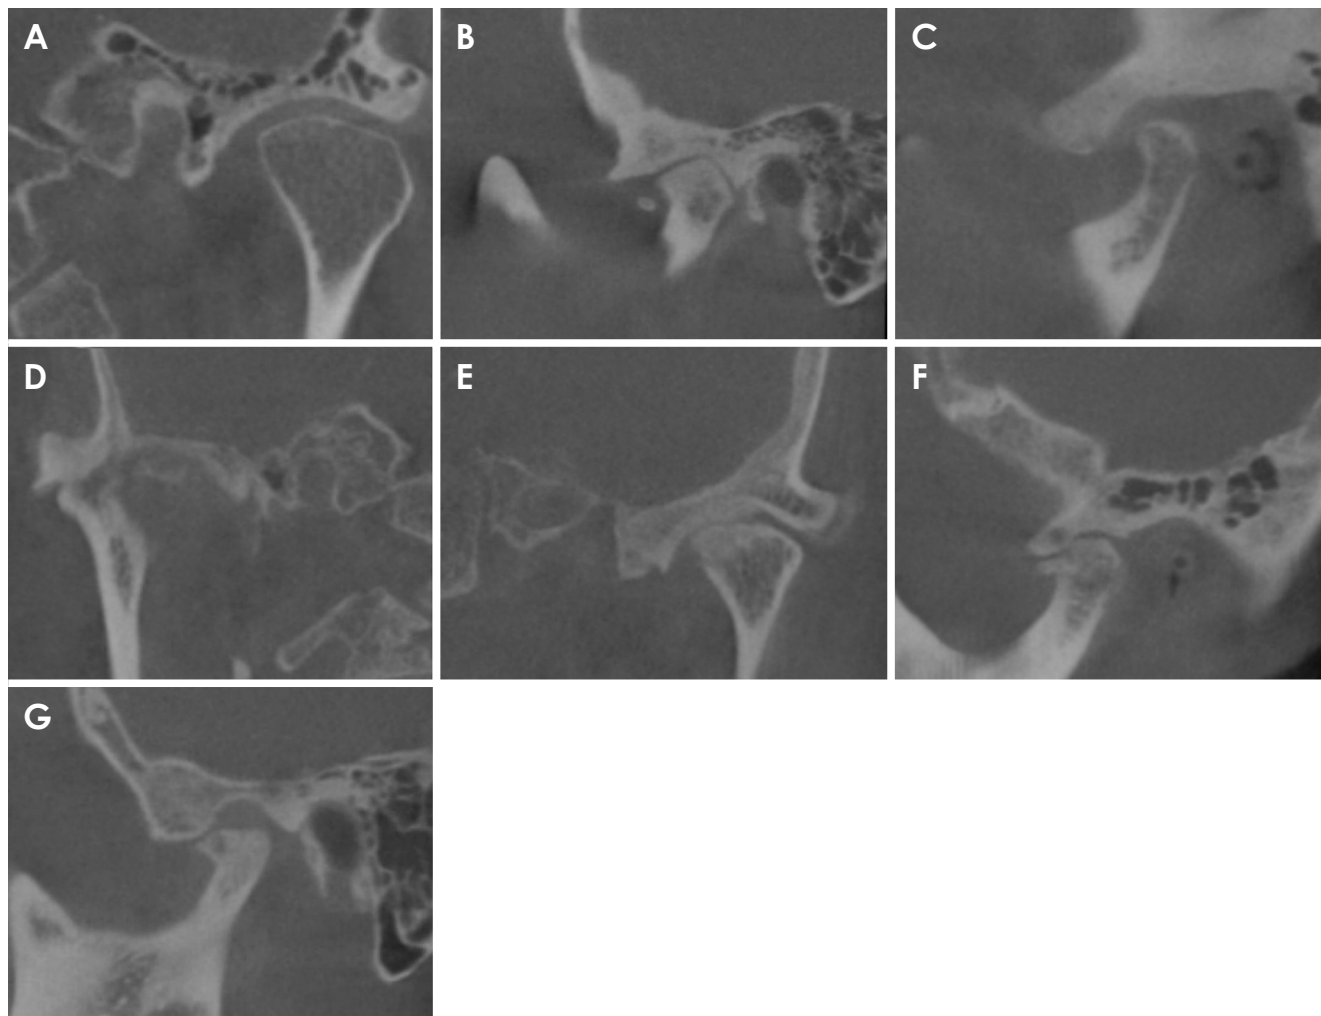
Sample cone-beam computed tomography images show bony changes in the temporal bone, selected from subjects in this study. A. Normal state (coronal view). B. Flattening (sagittal view). C. Erosion (sagittal view). D. Osteophyte (coronal view). E. Subchondral sclerosis (coronal view). F. Subchondral pseudocyst (sagittal view). G. Thickening of glenoid fossa.
